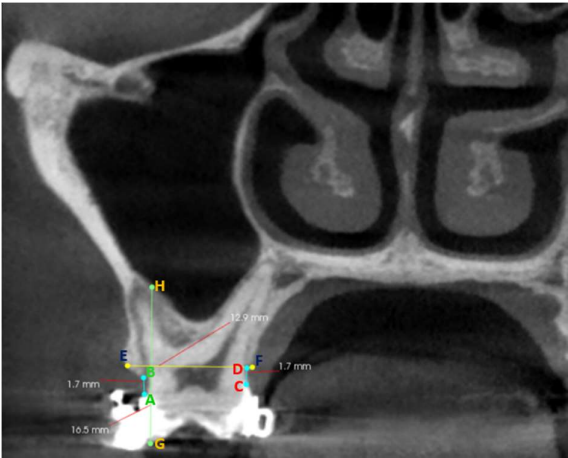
(a)- Pre-retraction CBCT measurement of alveolar bone height,width and vertical changes
